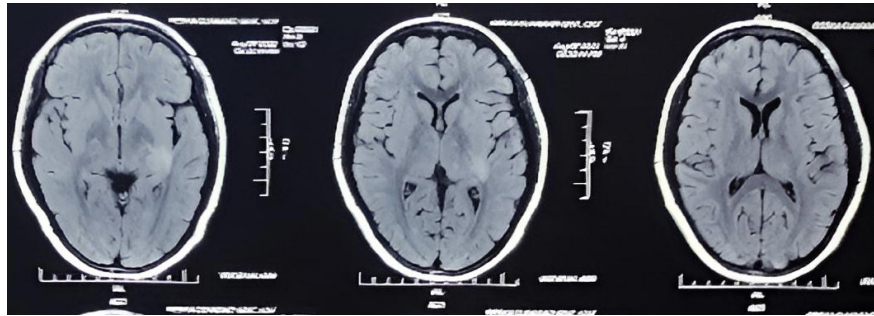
Hyperintense T2/FLAIR Axial images on left insular lobe and adjacent thalamus.
